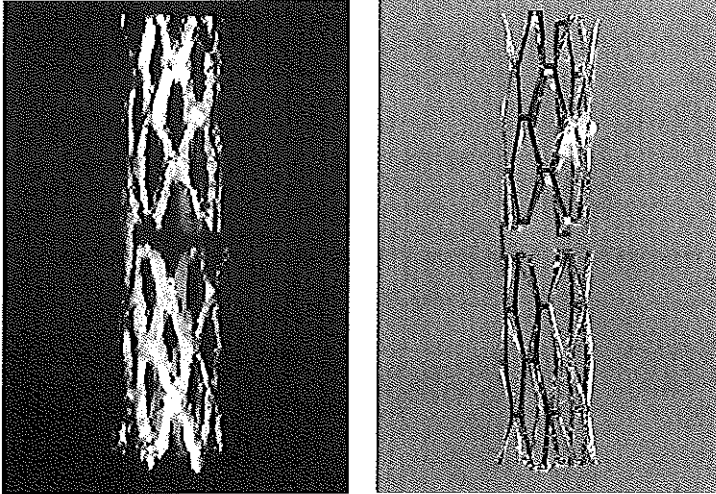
In vitro three-dimensional intracoronary ultrasound reconstruction (left panel) of a Palmaz-Schatz stent (Johnson & Johnson, Warren, U.S.A.) (right panel) based on segmentation by thresholding. The articulation of the Palmaz-Schatz stent and the typical strut pattern can be easily distinguished. (Reproduced with permission^[20].)
